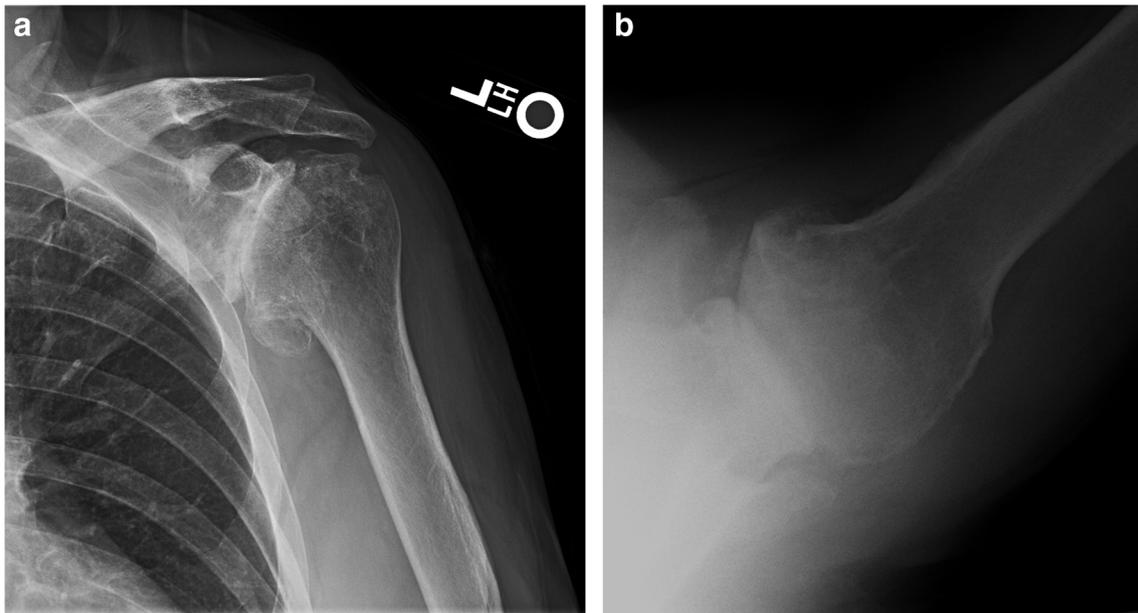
Case 1. a Pre-operative AP and b axillary radiographs showing severe degenerative joint disease and a type A2 glenoid
